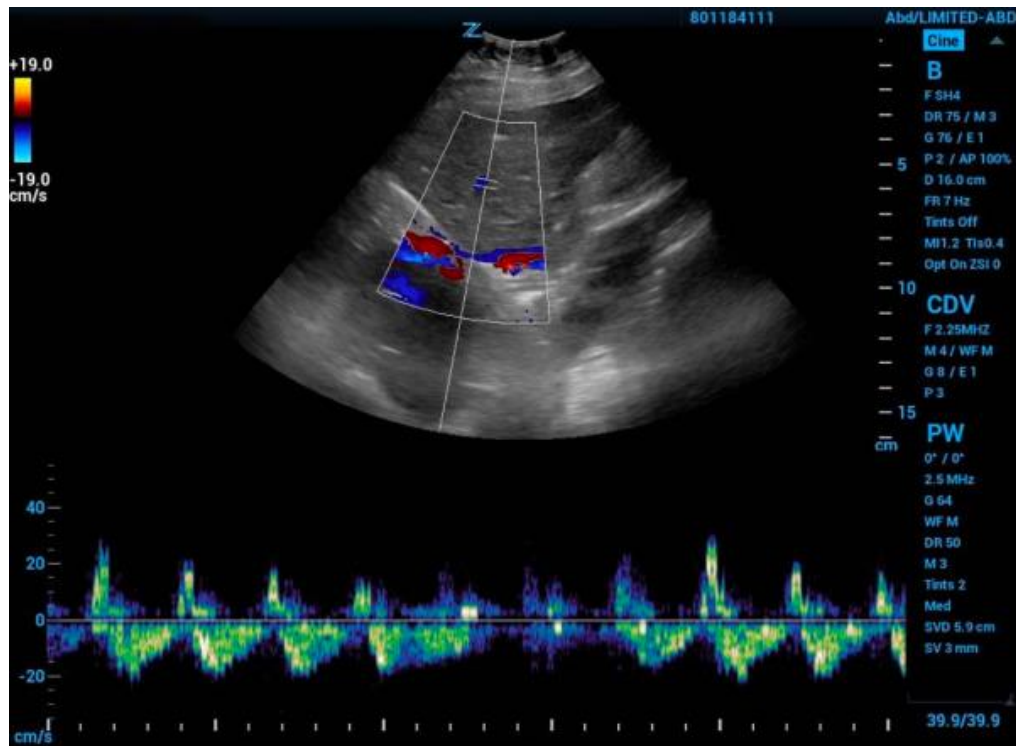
Hepatic vein Doppler with severe abnormality grade tracing⁸⁸
